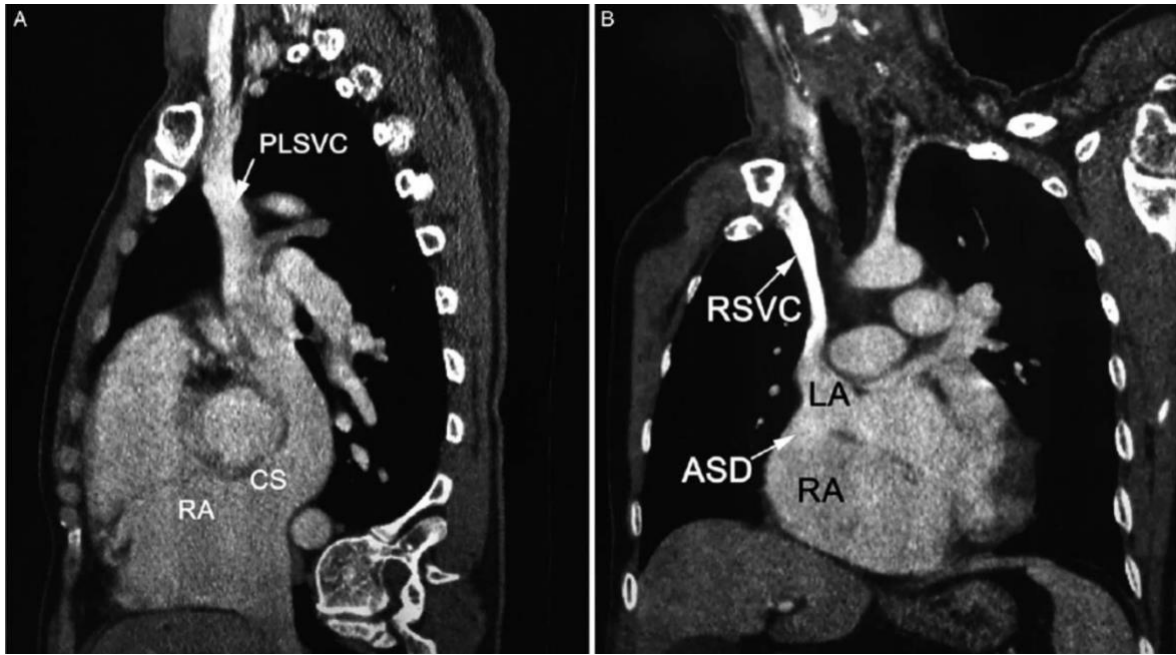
Cardiac Multidetector CT Indicating PLSVC Presence with Special Case of RSVC Drainage into LA(61)
